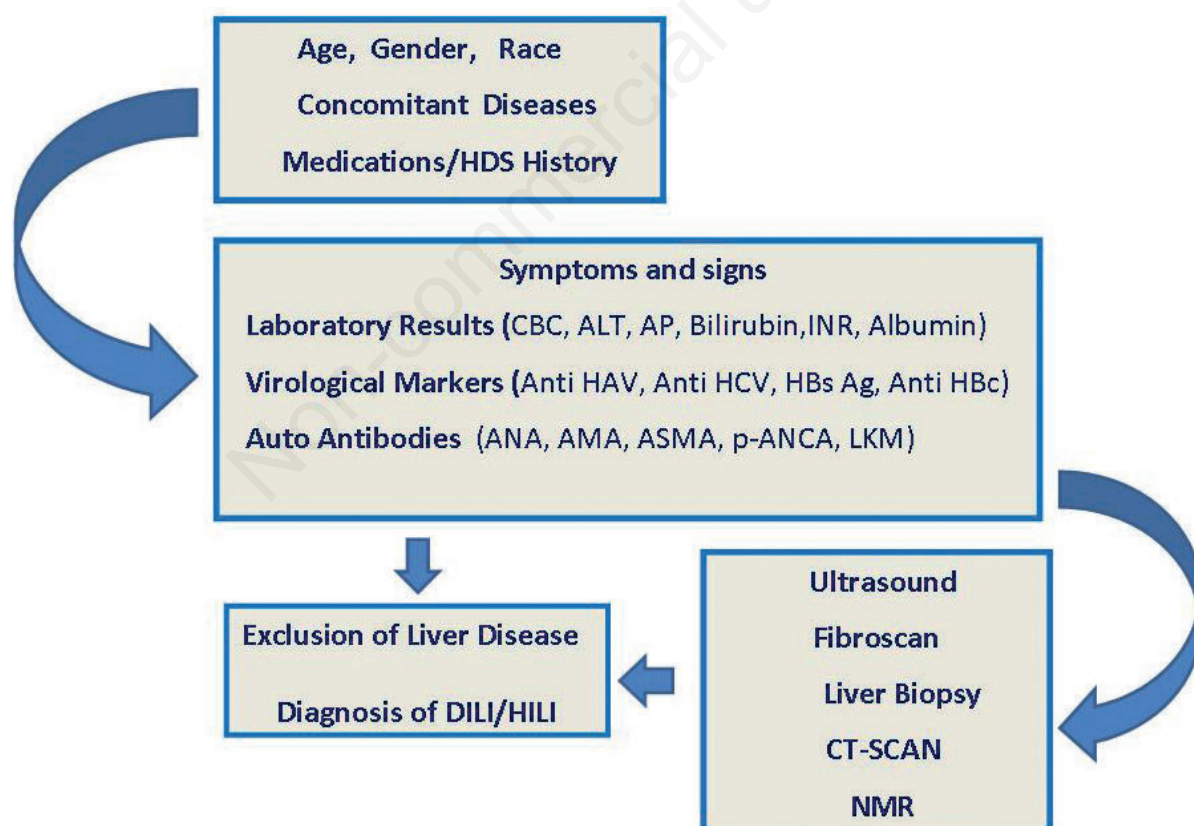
Algorithm to diagnose drug-induced liver injury. HDS, herbal and dietary supplements; CBC, complete blood count; ALT, alanine aminotransferase; AP, alkaline phosphatase; INR, international normalized ratio; Anti HAV, hepatitis A virus antibodies; Anti HCV, hepatitis C virus antibodies; HBs Ag, hepatitis B surface antigen; Anti HBc, hepatitis B core antibodies; ANA, antinuclear antibodies; AMA, antimitochondrial antibodies; ASMA, antismooth muscle antibodies; p-ANCA, anti-neutrophil cytoplasmic antibodies; LKM, antimicrosomal liver kidney antibodies; DILI, drug-induced liver injury; HILI, herbal-induced liver injury; CT-scan, computed tomographic scan; NMR, nuclear magnetic resonance.
